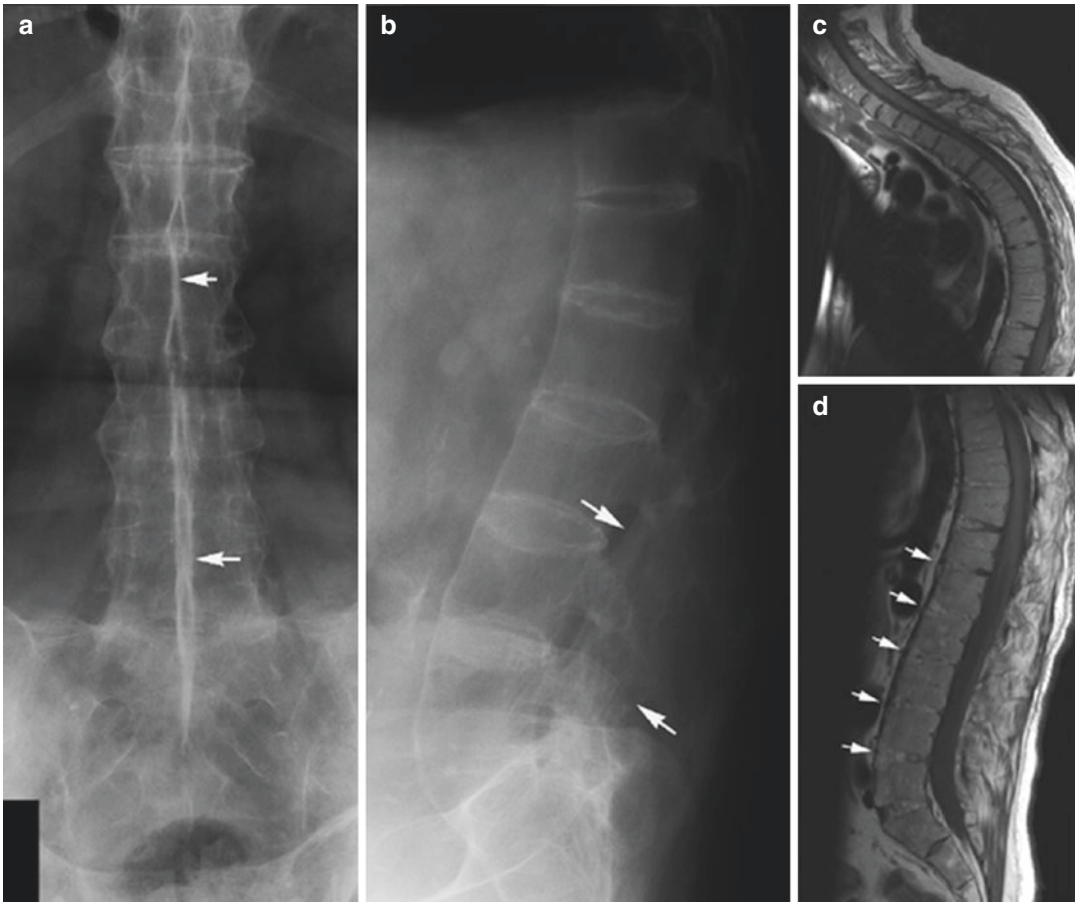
A 55-year-old man with advanced AS. (a) AP and (b) lateral radiographs of the lumbar spine demonstrate the characteristic squared vertebral bodies, syndesmophytes, and fusion of the facet joints (arrows), resulting in a “bamboo spine.” Corresponding sagittal, T1-weighted
